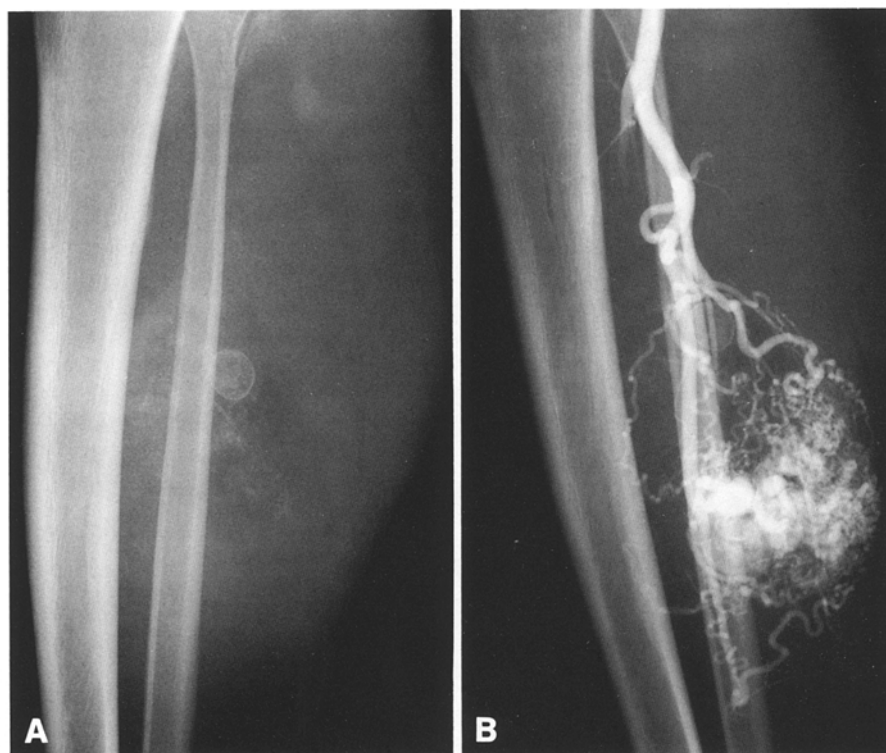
A, B. A 28-year-old man with an intramuscular hemangioma in lateral head of soleus (arteriovenous type) by angiographic demonstration. A Plain radiograph of right leg shows large soft-tissue mass and several phleboliths, varying in size. B Arteriogram shows enlarged and tortuous anterior and posterior tibial arteries, arteriovenous shunting, as well as pooling of contrast into small lakes
